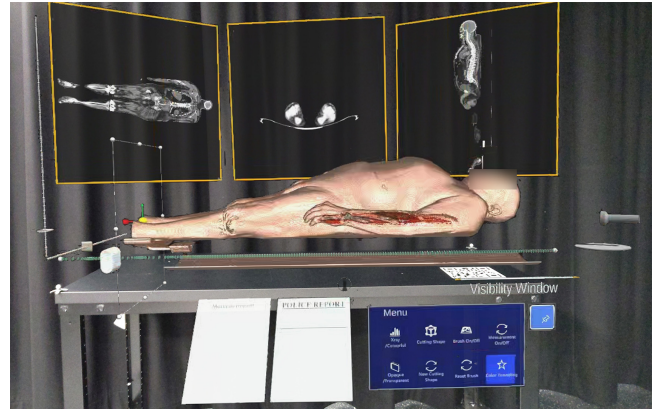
Prototype I: mixed-reality system concept with whole-body volume visualisation, CT images analytical tools and police and medical reports through Microsoft HoloLens 2.
